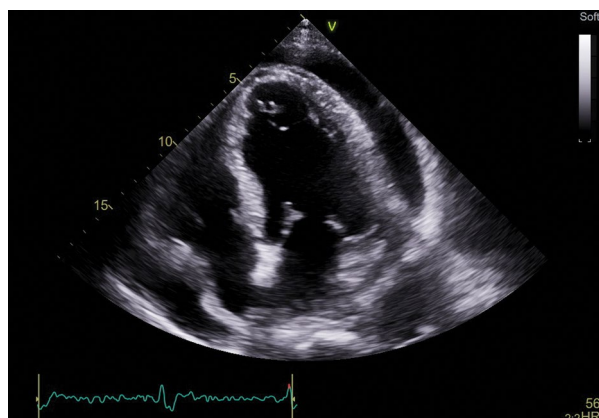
A significant amount of fluid in the pericardial sac as seen on a transthoracic echocardiographic examination
